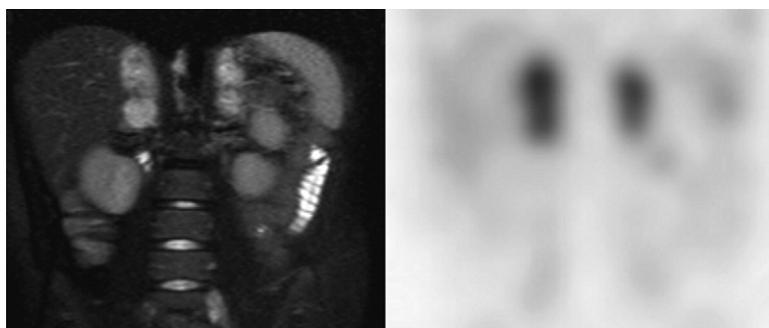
Bilateral phaeochromocytoma in a 10-year-old boy who presented with hypertension. MRI (A, T2 fat suppressed) shows bilateral adrenal masses. The ^{123}I -MIBG study (B, coronal SPECT) confirms marked uptake within the masses, but no other abnormalities were found within the body.
